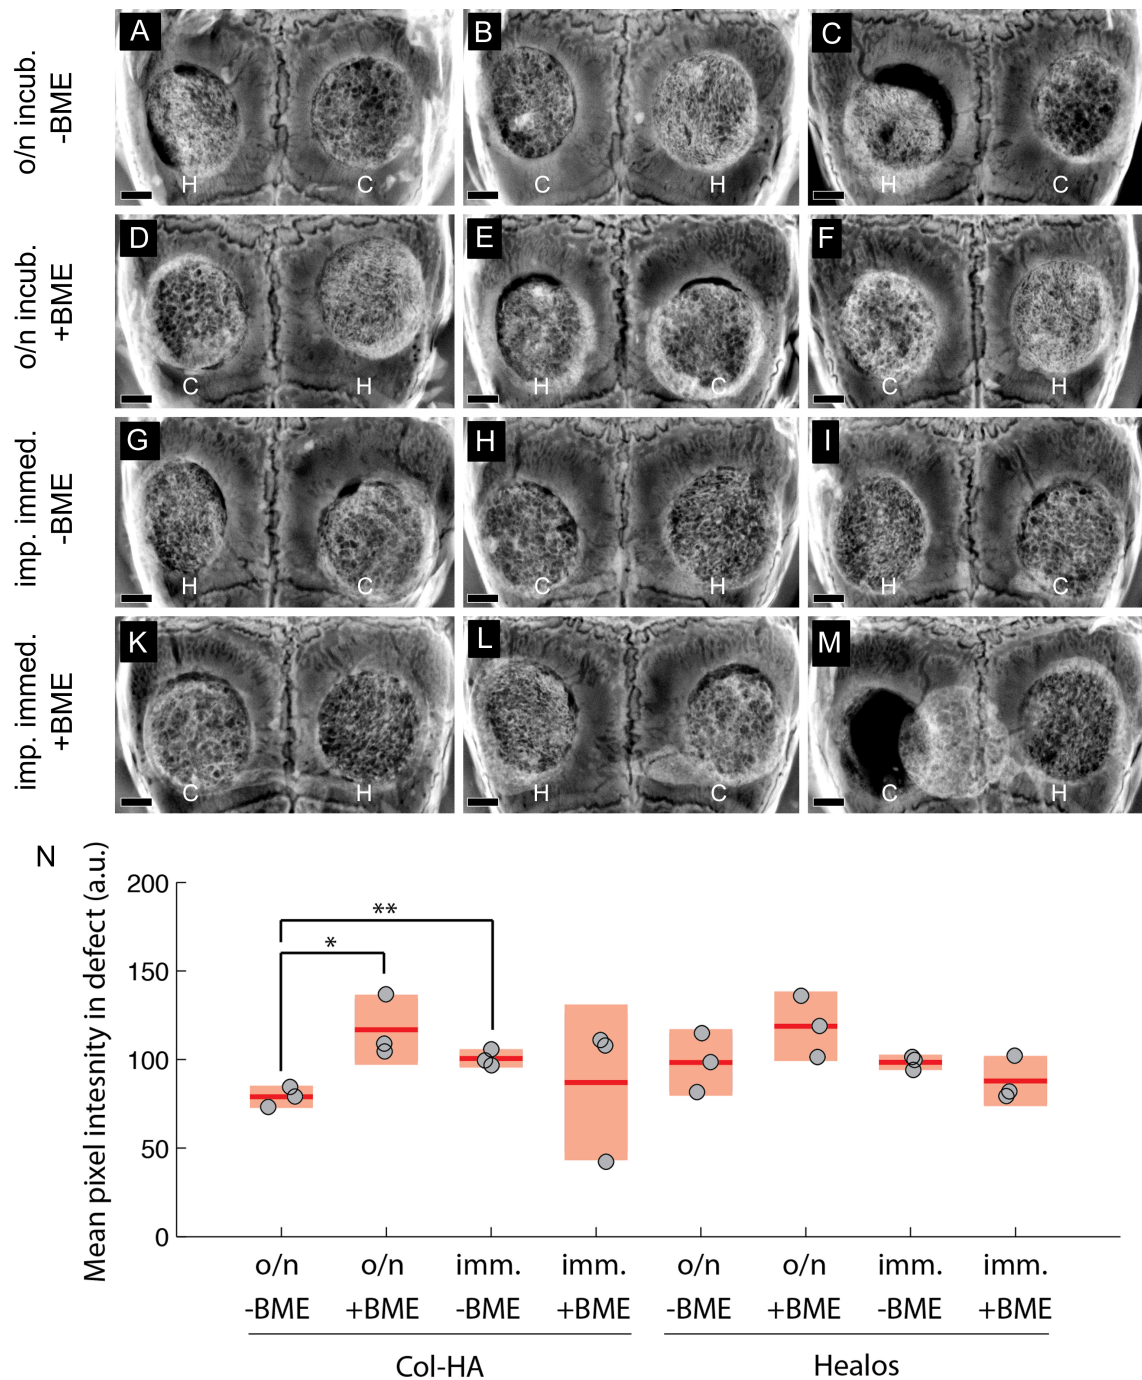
Radiographs of cell-scaffold constructs after 3 weeks *in vivo*. (A)-(M) H and C denote Healos and Col-HA scaffolds, respectively. Scale bars are 1 mm. (N) Quantitation of radiographs. Light red bars indicate 95% confidence intervals and blue bars indicate one standard deviation.
